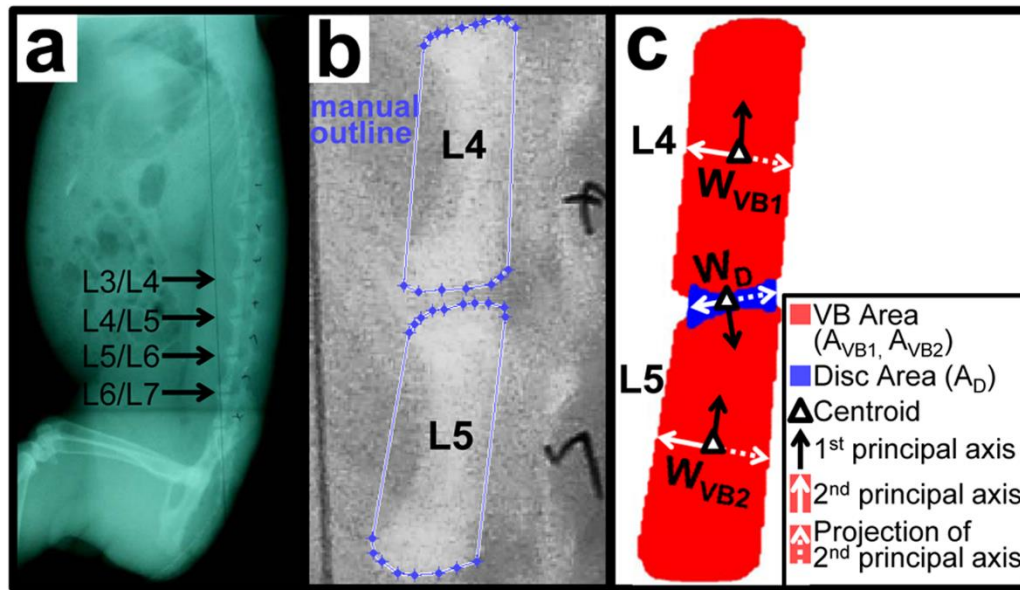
1 Radiographic analysis of response to injury (a) Representative lateral radiograph with the location of punctured lumbar discs identified. (b) Manual outline of vertebrae for disc height analysis. (c) Features used for the analysis of disc height, vertebral width (W_{VB1} , W_{VB2}) and disc width (W_D), vertebral area (A_{VB1} , A_{VB2}) and disc area (A_D), and 1st and 2nd principal axes generated by principal components analysis.
